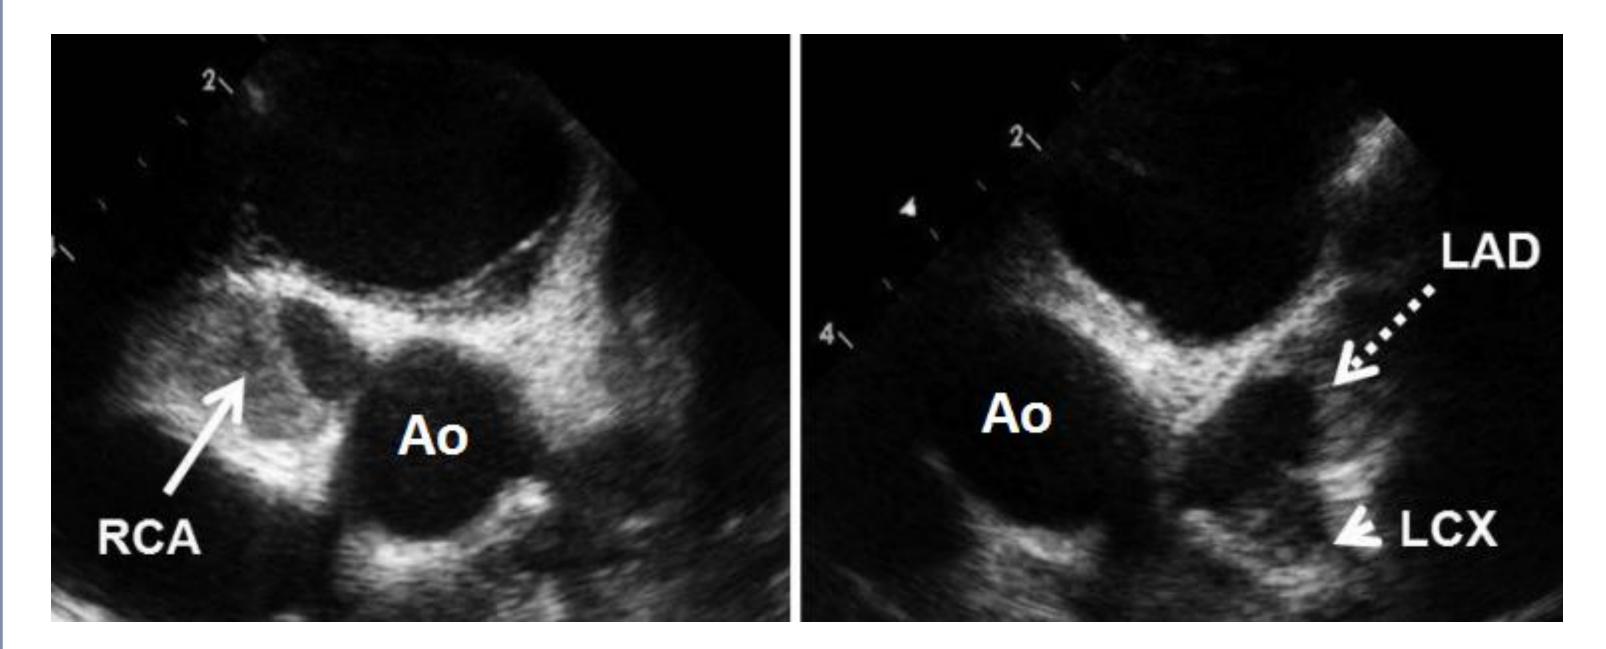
Coronary artery aneurysms: Echocardiogram showing proximal right coronary artery (RCA) aneurysm (left) and proximal left anterior descending (LAD) and circumflex (LCX) aneurysms
